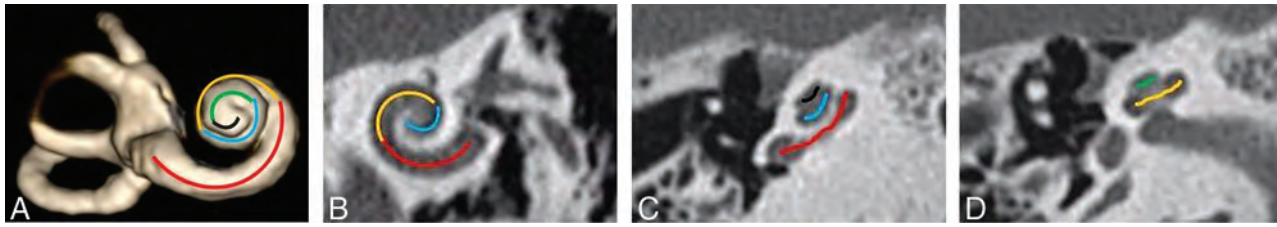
A, Fifths of a cochlea, as demonstrated on a 3D reconstruction of the inner ear from a heavily T2-weighted sequence (3D DRIVE). The first fifth is in red (including the hook region), the second fifth in orange, the third fifth in blue, the fourth fifth in green, and the fifth fifth in black. (B, C, and D). CT of the temporal bone in a bone algorithm in the Stenvers view (B) and axial (C and D) planes shows the fifths of the cochlea in the same color scheme as depicted on the 3D model in A.
